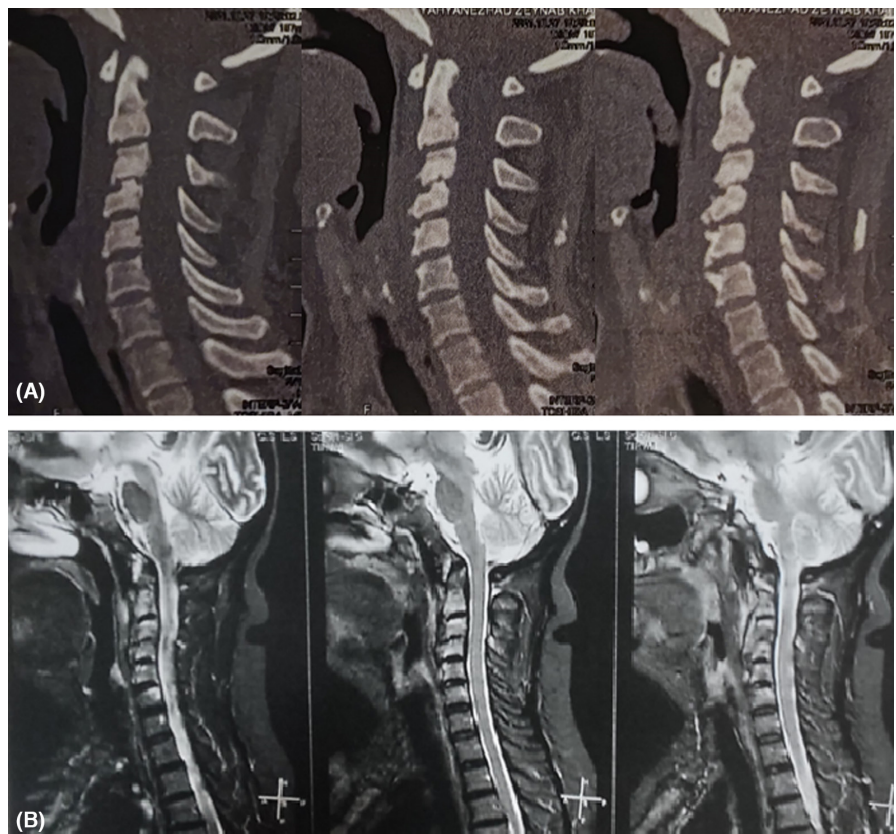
Evidence of cervical spondylitis and C1-C2 Instability. A. CT scan revealing erosions and sclerosis in body of C2 to C5 vertebrae and posterior aspect of Odontoid process. B. Cervical MRI, STIR sequence, C1-C6 body hyperintensities and mild surrounding soft tissue edema in favor of inflammation
